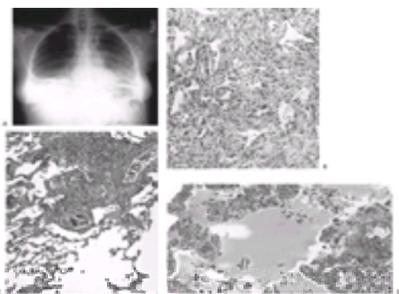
Methotrexate pulmonary toxicity. Alveolar infiltrates, primarily in the bases and bilateral pleural effusions, characterize this disease (A). These radiographic findings are consistent with either acute pneumonitis, hypersensitivity pneumonitis, or noncardiogenic pulmonary edema. These entities can be distinguished only by the clinicopathological findings (B–D). Acute pneumonitis produces expansion of the alveolar walls by a polymorphous inflammatory cell infiltrate. In this section, the pneumocytes exhibit moderate atypia (B). With hypersensitivity pneumonitis, there may be patchy interstitial lymphocytic infiltrates and associated bronchiolitis and granuloma formation (C). The pathological findings of pulmonary edema include expansion of the alveolar spaces by proteinaceous fluid (D).
